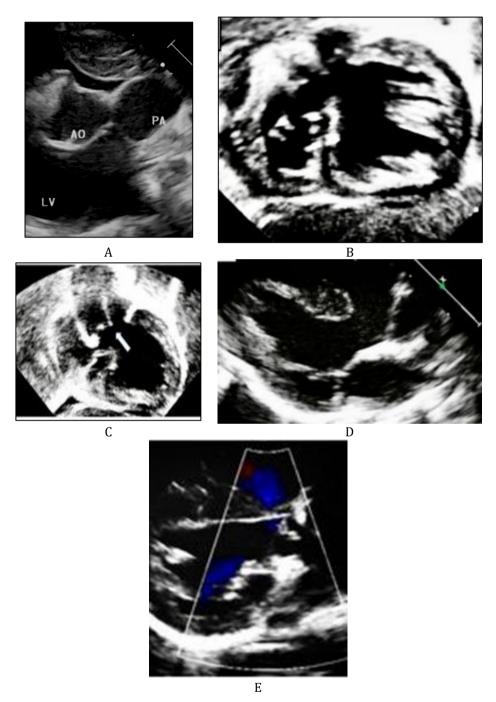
(A) 2D Echocardiographic parasternal short-axis view documenting both great arteries originating from the morphological left ventricle. (B) Echocardiographic and (C) subcostal view showing double-outlet left ventricle, subaortic VSD, d- transposed. (D, E) Parasternal long-axis view documenting mitro-aortic discontinuity and mitro-pulmonary continuity in a patient
